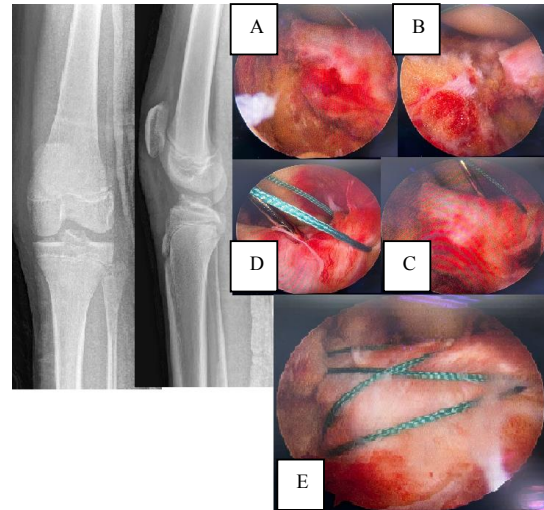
Preoperative radiograph (type IIIA tibial eminence avulsion fracture). Complete tibial eminence avulsion fracture (A). Debridement and preparation of ACL footprint on tibia (B). Ethibond suture passed through avulsed ACL (C), (D), Final fixation with 2 loops Ethibond (E).
